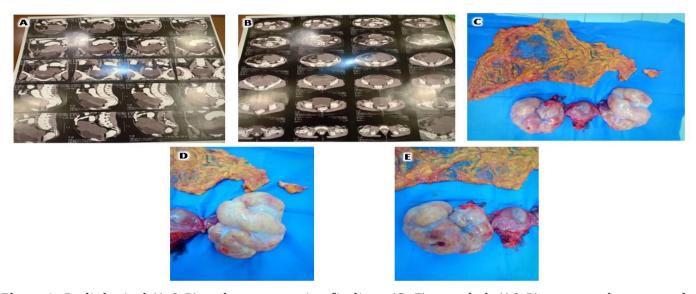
Radiological (A & B) and postoperative findings (C- E) revealed: (A& B) computed tomography (CT) scan, which revealed bilateral a \sim 20-cm solid mass arising from both ovaries and did not reveal any lesions in the gastrointestinal tract. (C- E) Both removed ovaries exhibited a mass, ranged in size from 30x20x15 to 20.5x16.5x11.5 cm, and had an intact, lobulated and smooth external capsular surface.
